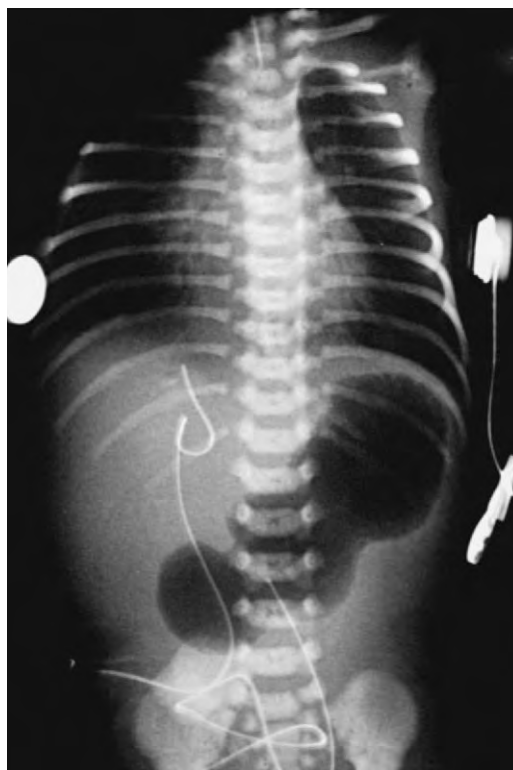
Classic plain film radiograph showing gastric outlet obstruction.
